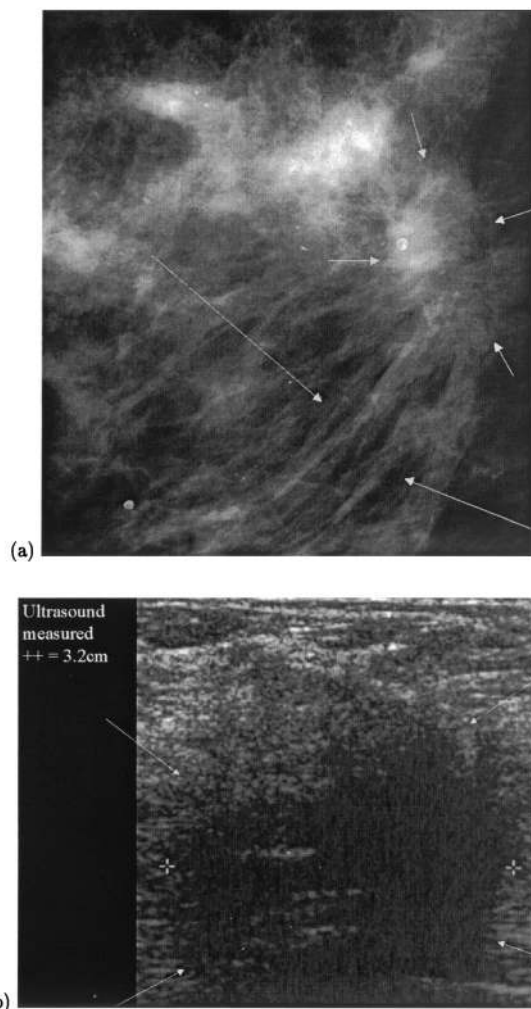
Conventional breast imaging of a left breast carcinoma. (a) Photographically magnified left mediolateral mammogram. Short arrows, poorly defined central tumor mass; long arrows, associated architectural distortion consisting of long lines radiating from the tumor. (b) Sonography in the longitudinal plane reveals a hypoechoic mass (arrows), and calipers (+) measure the maximal diameter of the tumor at 3.2 cm.
